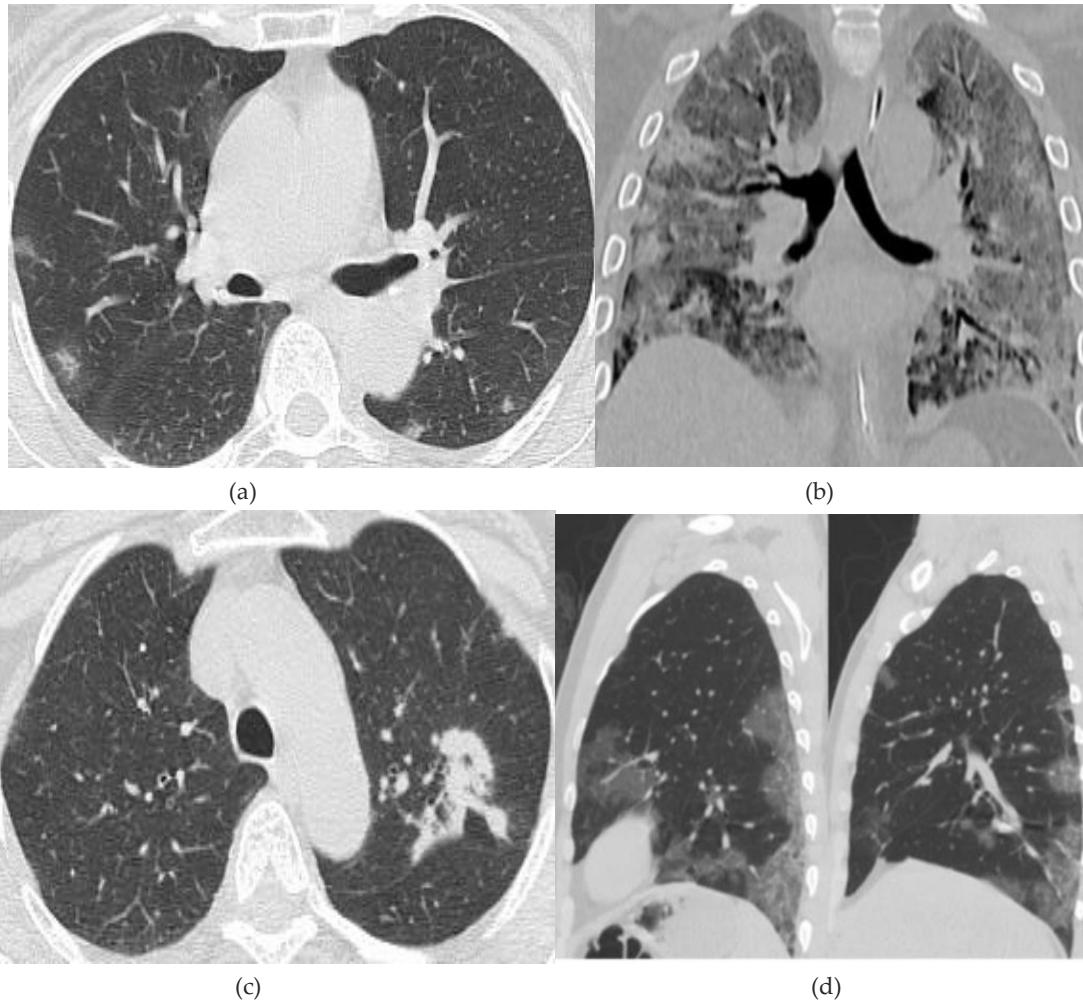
(a) Axial section of HRCT chest scan shows mild ground glass opacities involving bilateral lung parenchyma. (b) Coronal section shows the severity of illness is indicated by a diffuse crazy-paving pattern with patches of consolidation in the periphery. (c) Axial section of HRCT chest scan shows Focal areas of Consolidation in the left lower lobe. (d) Sagittal thin-section of HRCT chest scan shows bilateral peripheral ground glass opacities of moderate severity.
